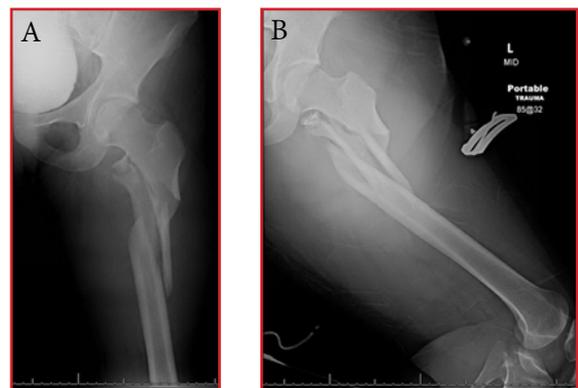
Preoperative radiographs of the left femur, revealing a closed subtrochanteric fracture. A) Anterior-posterior view. B) Lateral view.
